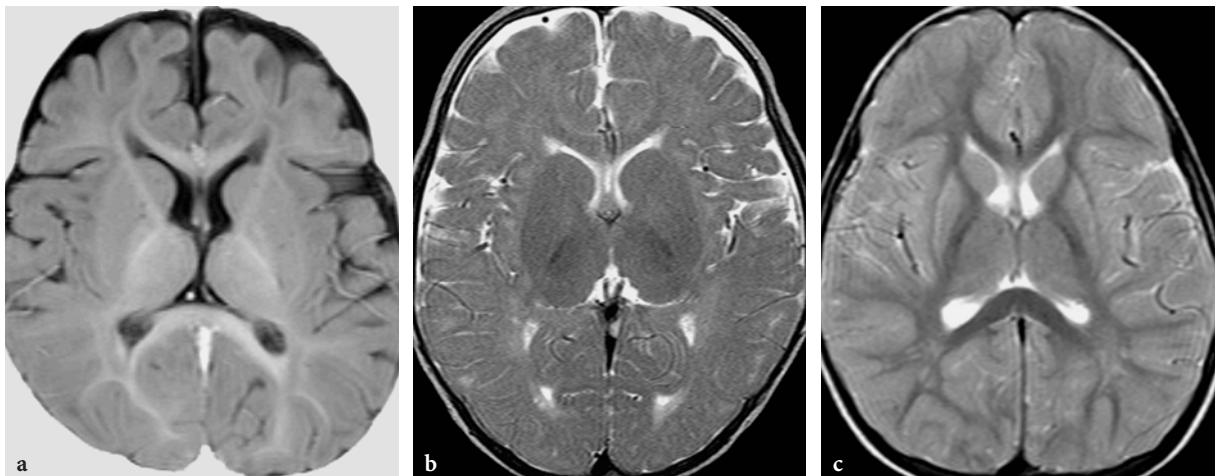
MR imaging findings in biotinidase deficiency. a Axial T1-weighted inversion recovery image in a 9-month-old female patient. The myelination is delayed for the age of the patient. Even in the occipital regions, the peripheral myelination is very poor. b Axial T2-weighted fast spin-echo image in a 17-month-old male patient. The myelination is far from being accomplished, the peripheral white matter is very poorly myelinated in all areas, but the anterior limbs of the internal capsules are hypomyelinated too. c Axial T2-weighted fast spin-echo image in a 3-year-old male patient. Diffuse paucity of the myelin within the cerebral hemispheres. Subtle signal abnormalities within the lateral parts of the putamina bilaterally in conjunction with slight atrophy
